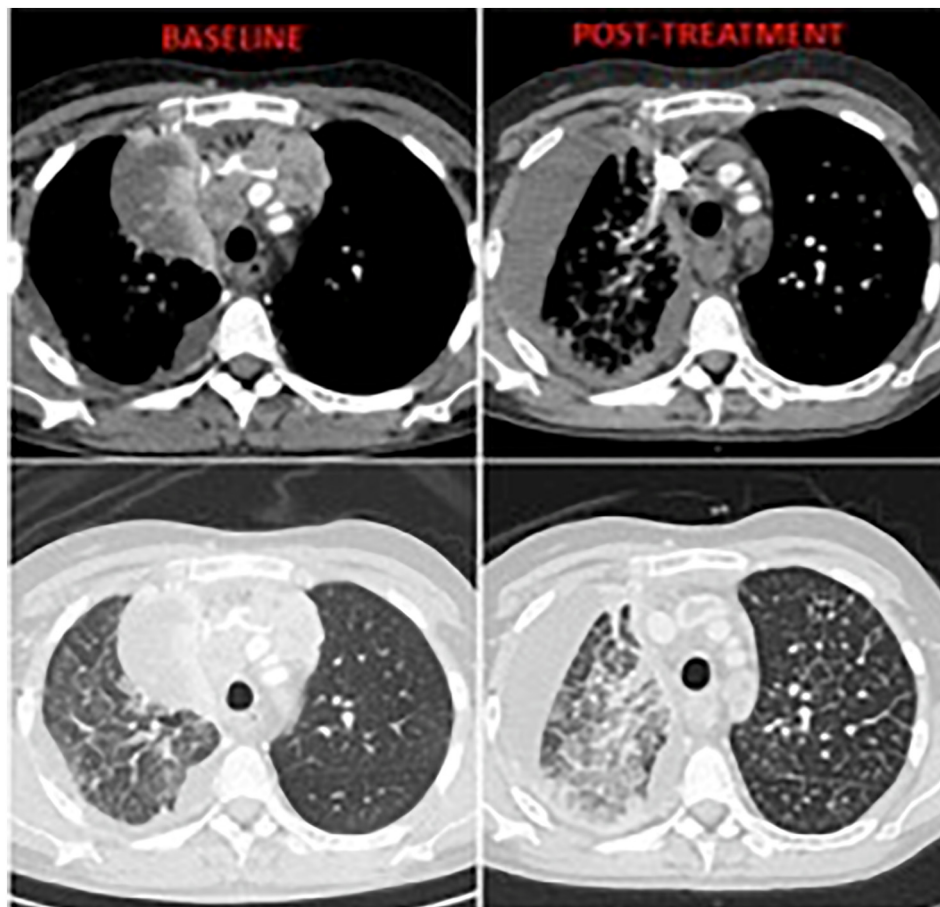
CT assessment before and after crizotinib treatment showing improvement in mediastinal lymphonodes enlargement with parallel worsening of pleural effusion and pulmonary interstitial disease.
